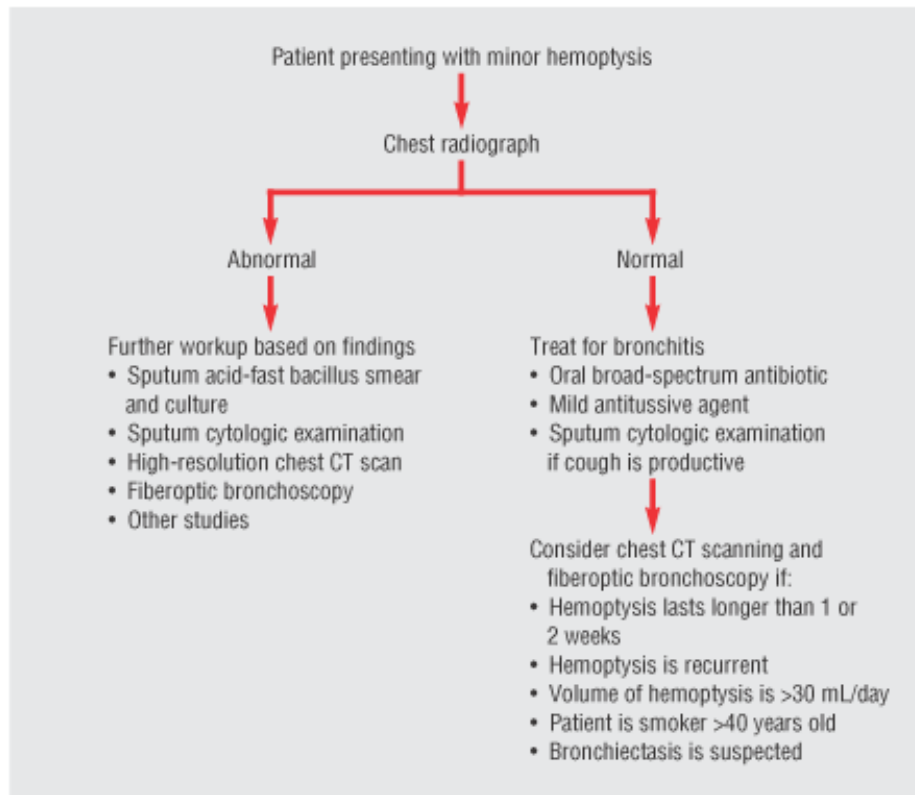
Management of minor hemoptysis. CT, computed tomographic.
